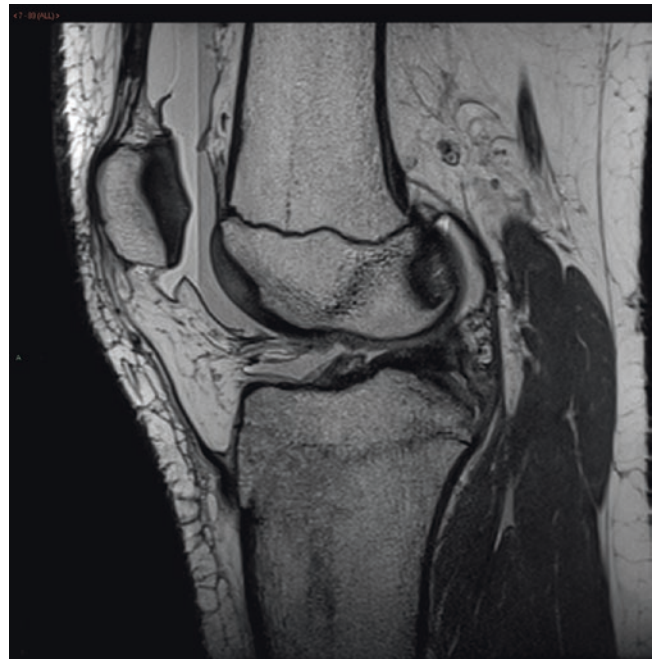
Lipohaemarthrosis on sagittal T1W MRI of the knee
